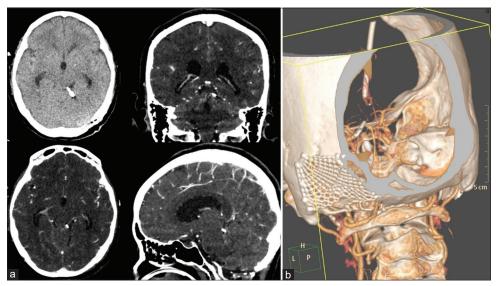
Postoperative computed tomography angiography (a) and 3D reconstruction (b) revealed the clip retention with no residual aneurysm in the cerebellomesencephalic segment of the left superior cerebellar artery, with preservation of the parent artery and vermian branch
